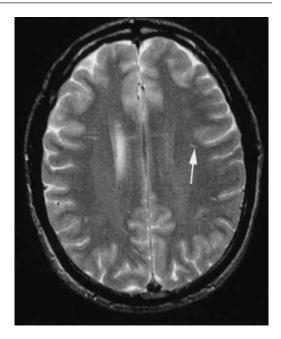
"Fast spin-echo T2-weighted image of an otherwise healthy young man 3 months after head trauma, demonstrating presumed gliosis in the periventricular white matter (*arrow*)". From Johnston et al. [249]. Reproduced with permission from Wolters-Kluwer
